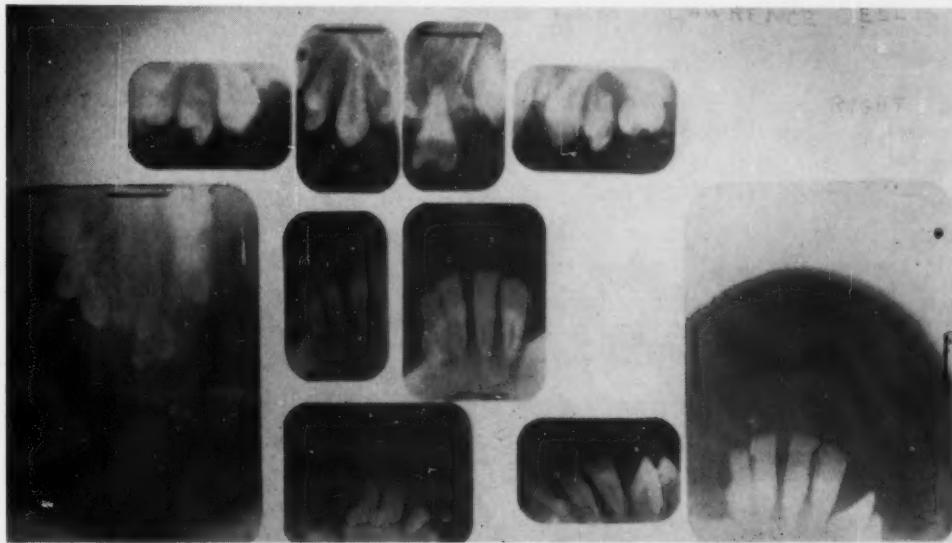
Roentgenograms of Patient L. E., aged 12 years 3 months.
